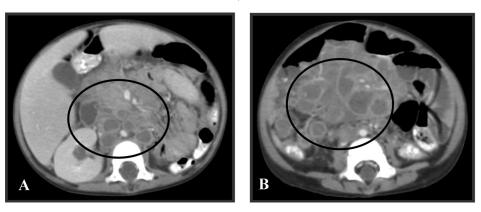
Lymphadenopathy. CT scan images from two different patients demonstrating lymphadenopathy (encircled) in the retroperitoneal area (Fig. 3 A) and mesentery (Fig. 3 B). The lymph nodes are clustered and enlarged with central necrosis and contrast enhancing rim.
